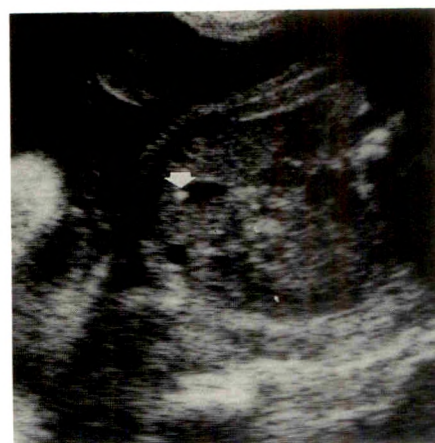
Prenatal gallstone. Prenatal sonogram of fetal abdomen shows echogenic shadowing focus in gallbladder (arrow). This stone was followed up postnatally until it ultimately resolved. Child had no associated risk factors for cholelithiasis. (Courtesy of M. Kirpekar, New York, NY.)
